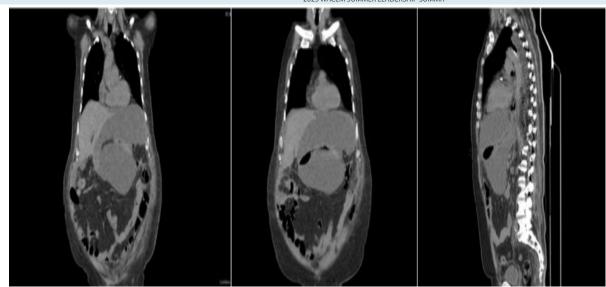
Pancreatic pseudocyst compressing the stomach in CT coronal and sagittal sections Discussion
